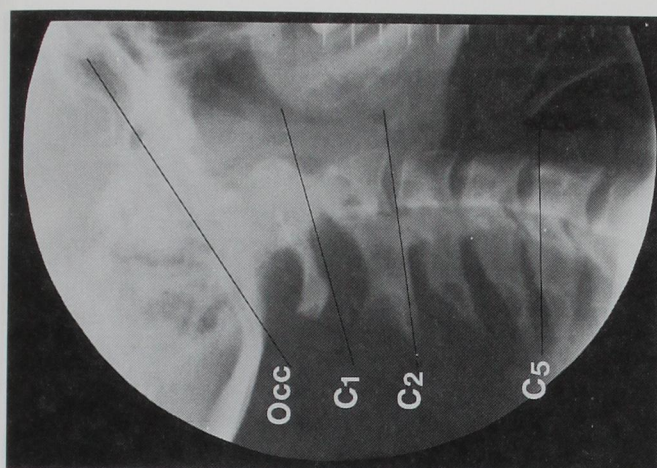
Representative radiograph showing the reference lines for the base of the skull (C0) and the cervical vertebrae (C1, C2, and C5) used to determine relative movement during laryngoscopy.
